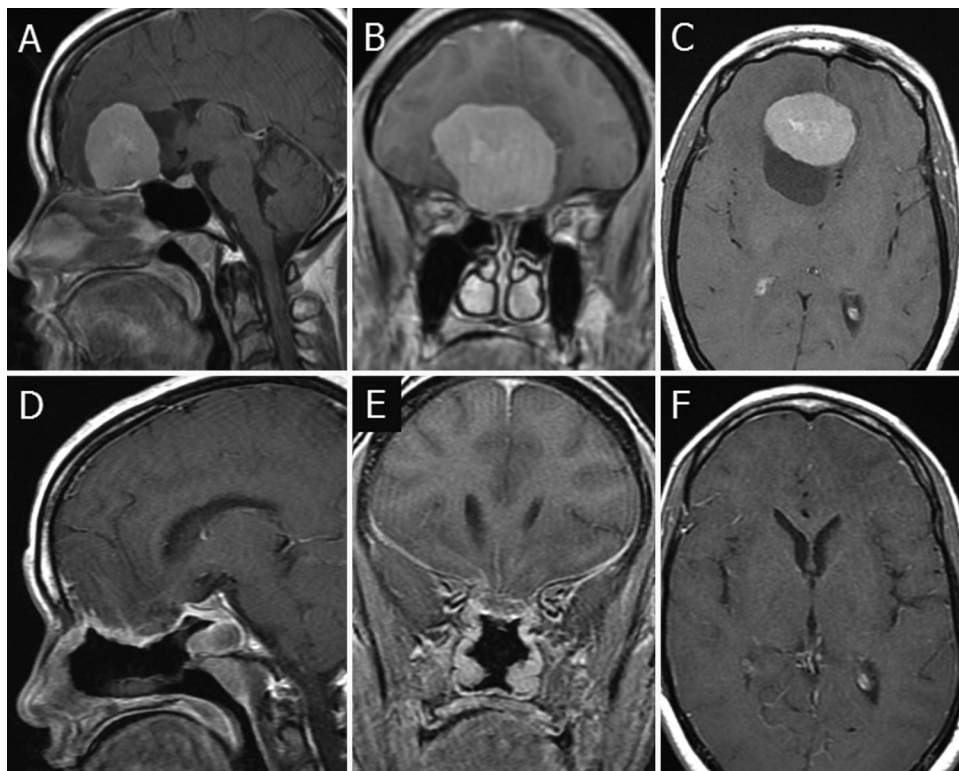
Case 1. A–C: Preoperative sagittal (A), coronal (B), and axial (C) T1-weighted Gd-enhanced MR images demonstrating a large olfactory groove meningioma extending from the cribriform plate to the tuberculum sellae. D–F: Delayed post-operative sagittal (D), coronal (E), and axial (F) MR images obtained 3 months after surgery demonstrating gross-total resection of the tumor achieved via an endoscopic endonasal approach. Basal enhancement represents granulation and reepithelialization of the AlloDerm reconstruction by the sinonasal mucosa.
